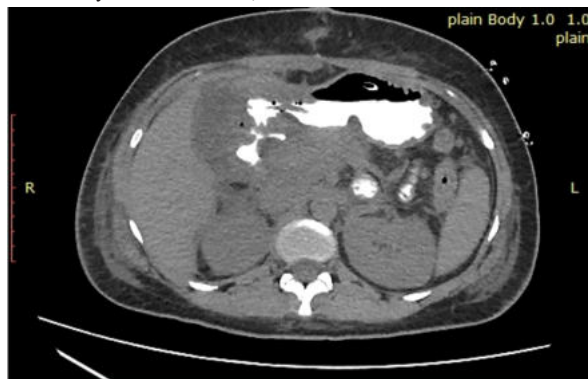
CT Abdomen with oral contrast showing no leak
